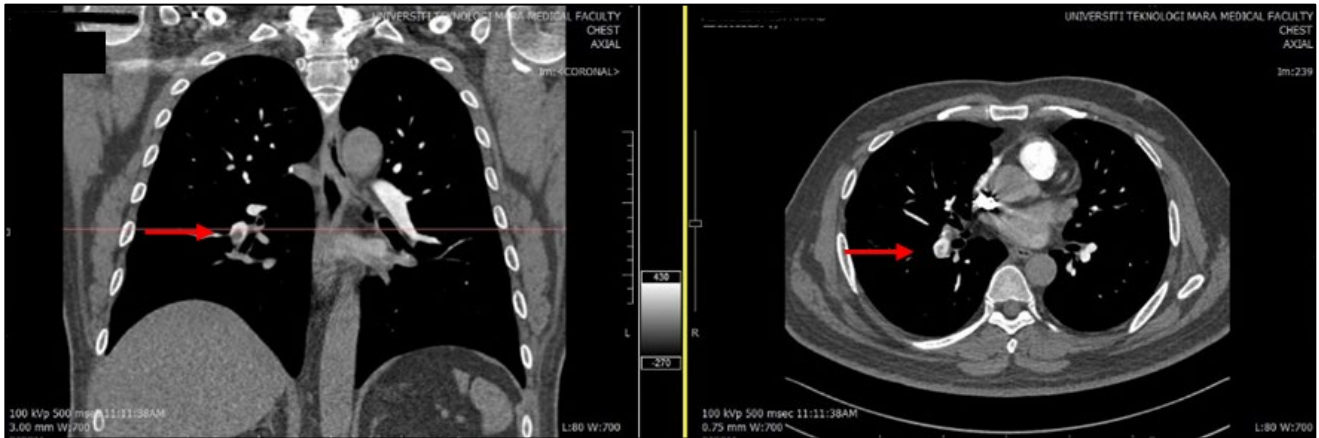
Selected CT images performed after COVID 19 infection at outpatient follow up review
